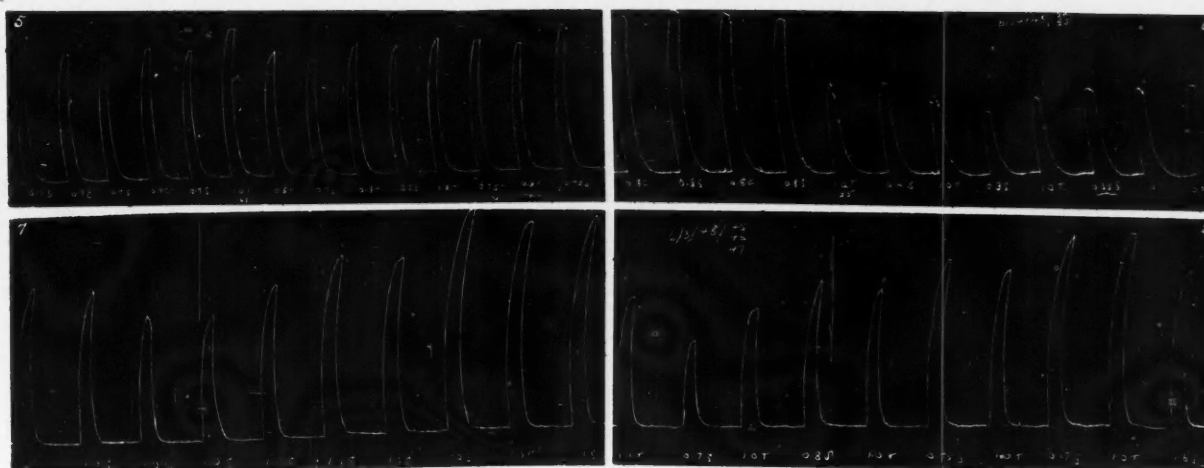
No. 65, age 24, Para I Gr. III. Pregnancy of 13 weeks. HI = 15. 0.8 c.c. of the test solution showed the same result as 0.7 c.c. of the standard. Fig. 6.—No. 55, J.M., age 21, Para I Gr. II. Pregnancy of 27 weeks. HI = 65. 1 c.c. of the test solution showed the same response as 0.35 c.c. of the standard. Figs. 7 and 8. No. 45, B.M., age 31, Para V Gr. VI. Pregnancy of 19 weeks. HI = 30. A-Z reported negative. X-ray confirmed pregnancy.
